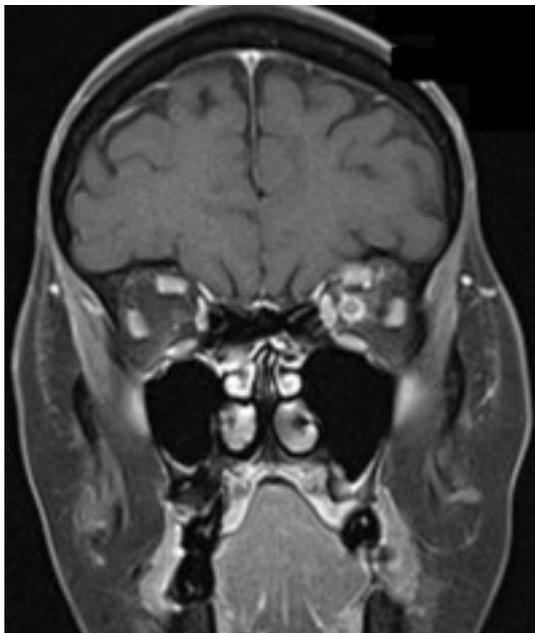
MRI-scan of brain and orbit showing increased thickening of left optic nerve as compared to previous scan (see Fig. 1), also with contrast enhancement of optic nerve sheath and retrobulbar fat
